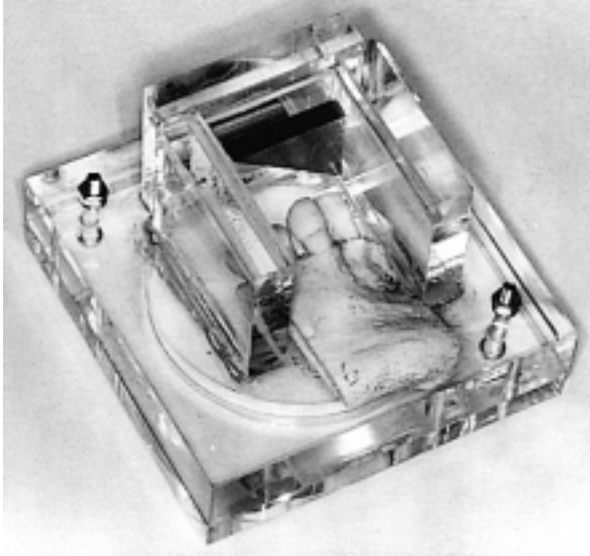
Radiographic object (including section of mandible), aluminum block (attached to aluminum wedge), acrylic plate, and ring for cone of x-ray machine.
